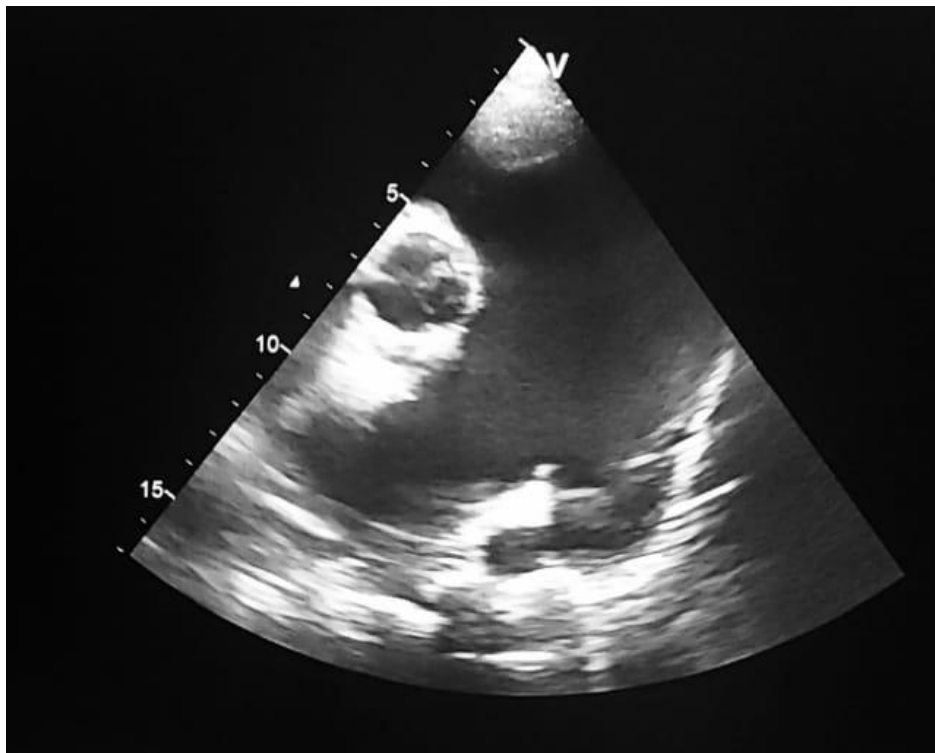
ETT 2D short-axis parasternal view centered on the pulmonary artery showing significant dilation of the trunk of the pulmonary artery and its branches
